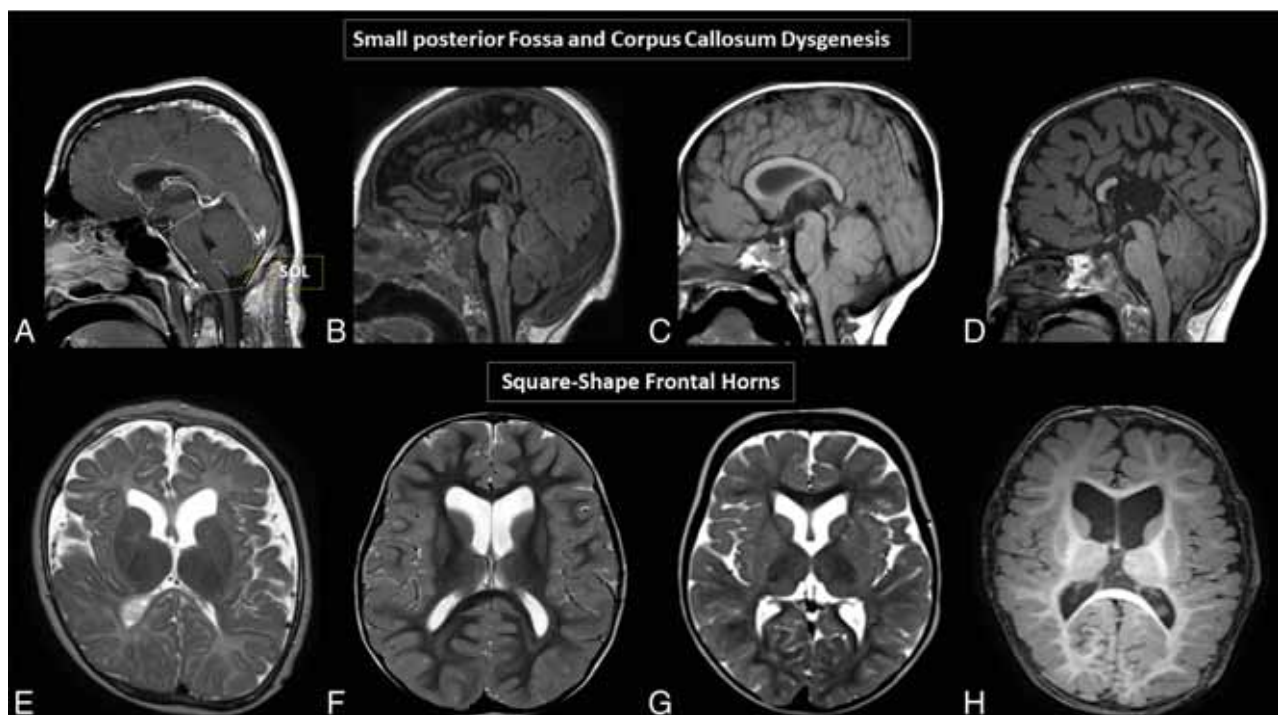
Brain MR images. A and D, Variable degrees of corpus callosum deformities, particularly involving the body and splenium, noting partial agenesis in D. Deformed morphology of the posterior fossa, with variable degrees of low insertion of the torcula and size reduction of the supraoccipital line (SOL). Note the crowded appearance of the structures in the posterior fossa along with low disposition of the cerebellar tonsils, fitting in the Chiari I deformity criteria in C and D. E-H, Variable degrees of reduced size and/or internal rotational appearance of the head of the caudate nuclei, resulting in an enlarged and squared appearance of the frontal horns.
